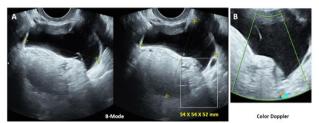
Collision of ovarian mature cystic teratoma and benign Brenner tumor (case 4). A: Transvaginal ultrasound (B-mode) identifying a cystic multilocular formation (4 locules), within the parenchyma of the right ovary, with regular external and internal borders and mixed content. B: Amplification of the area within the white rectangle from A, demonstrating no vascularization by the use of Color Doppler. No intra-cystic flux has been detected in whole lesion. Benign Brenner tumor, typically solid non-vascularized or minimally vascularized lesion, has not been preoperatively or intraoperatively recognized.
